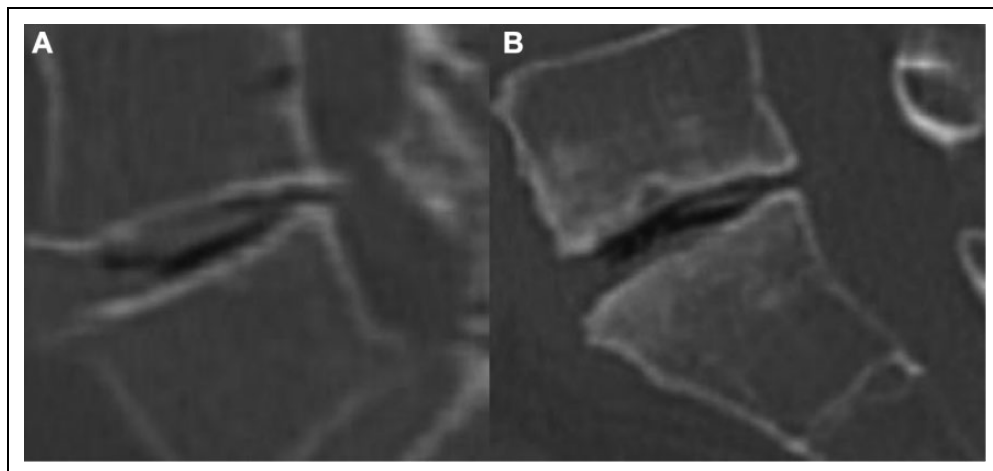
Partial vacuum phenomenon. (A) Sagittal CT at L4-L5 with vacuum and minimal sclerosis (type 2A). (B) Sagittal CT at L5-sacrum with vacuum and subchondral sclerosis (type 2B).
